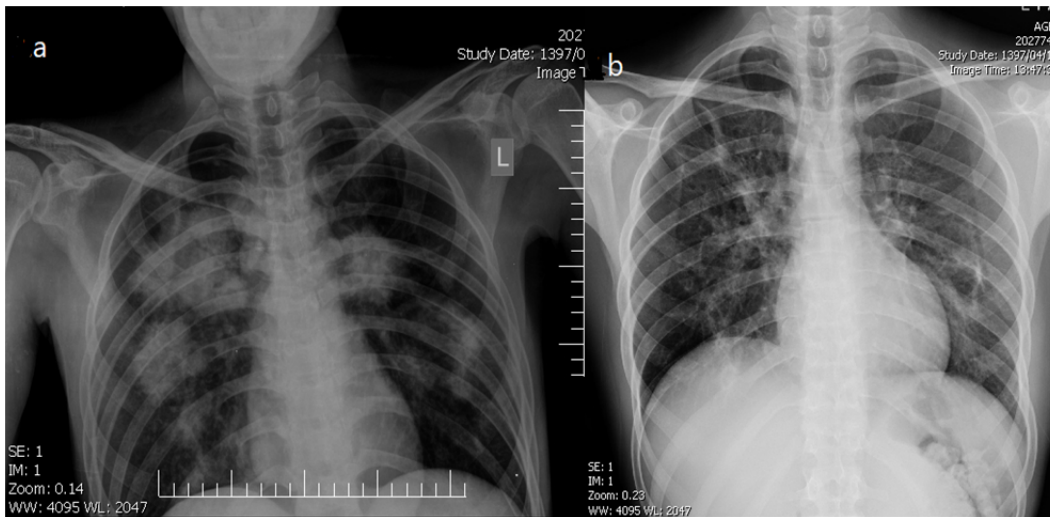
Chest radiographs of the patient before starting corticosteroid therapy (a) and 72 hours after starting medication (b) revealing dramatic regression of interstitial opacities in response to the treatment.
